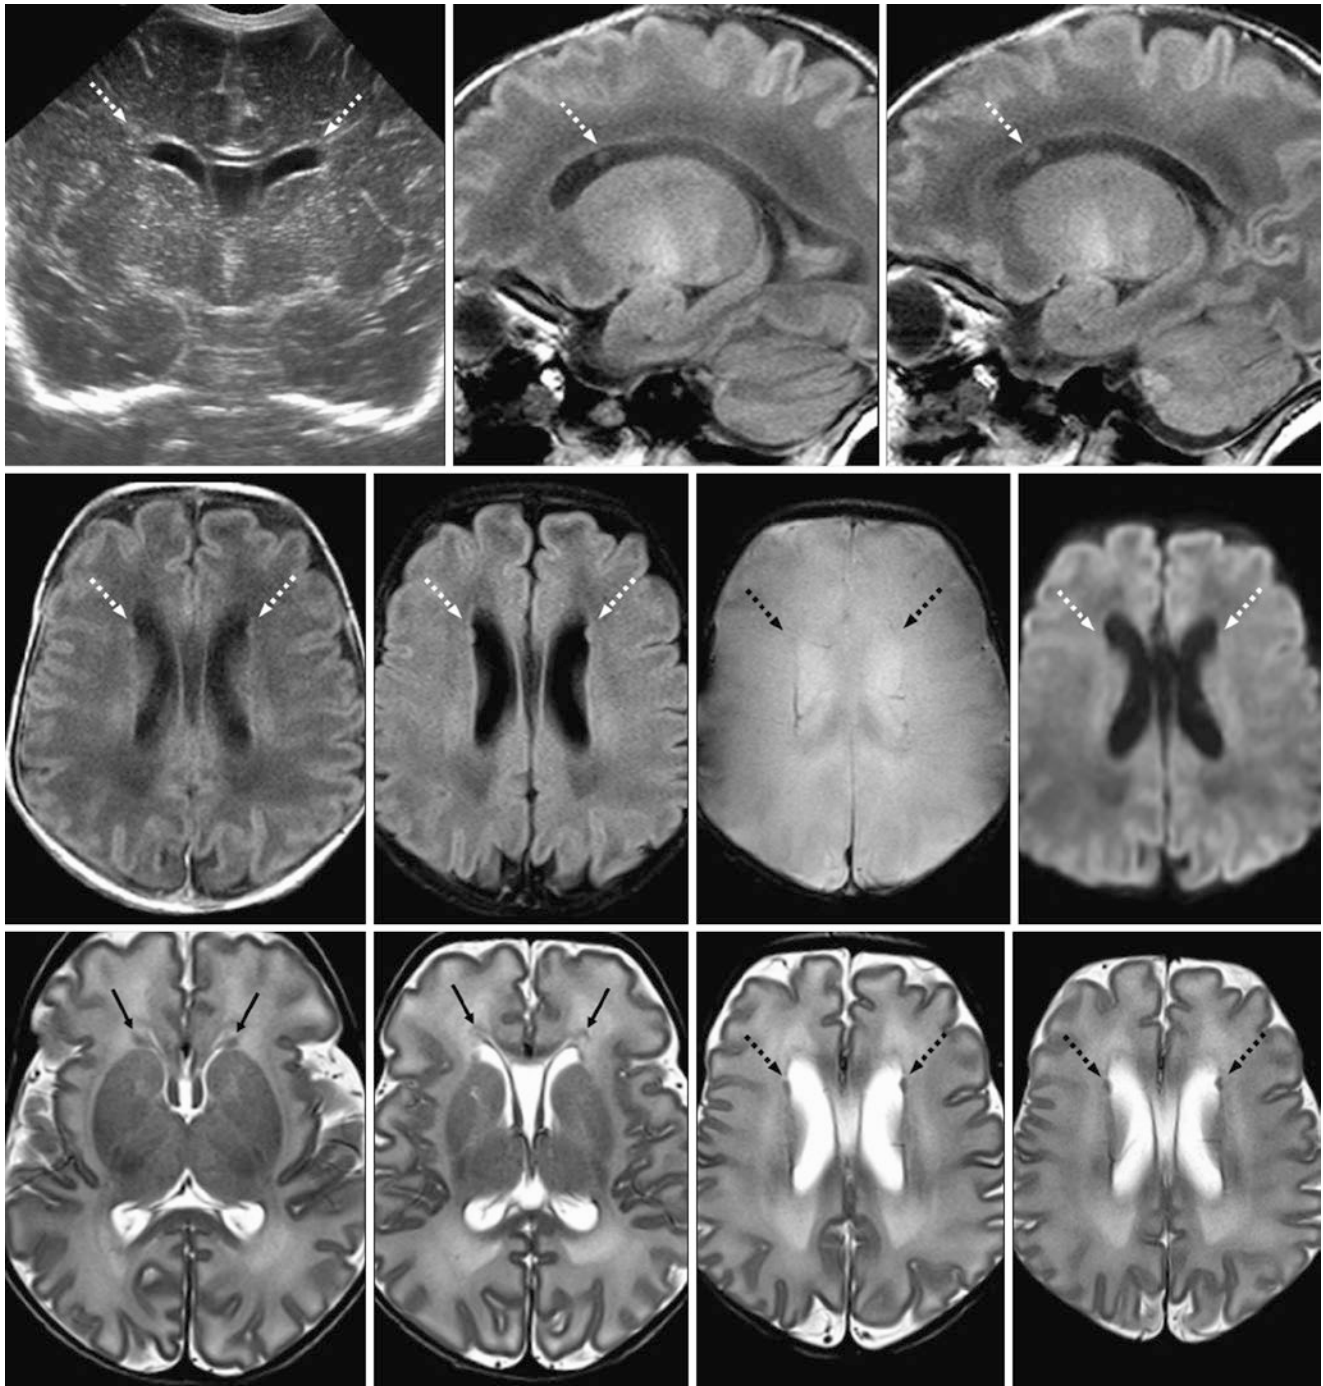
Comparison case of tiny periventricular nodular heterotopia (PVNH). A 7-day-old infant born at 37 weeks gestational age had respiratory depression. An ultrasound and a 3T MRI were both requested. The ultrasound was interpreted as normal. *Top row:* Coronal ultrasound (*left*) appears relatively normal. On the 3T MRI, sagittal GE T1WIs of the right (*middle*) and left (*right*) sides demonstrated tiny nodular foci (*dotted arrows*) adjacent to the frontal horns of the lateral ventricles. The sulcal pattern is slightly less than expected at 37–38 weeks, appearing like a 35- to 36-week-old. *Middle row:* Axial GE T1WI (*left*), FLAIR (*left middle*), GE T2*WI (*right middle*), and DWI
